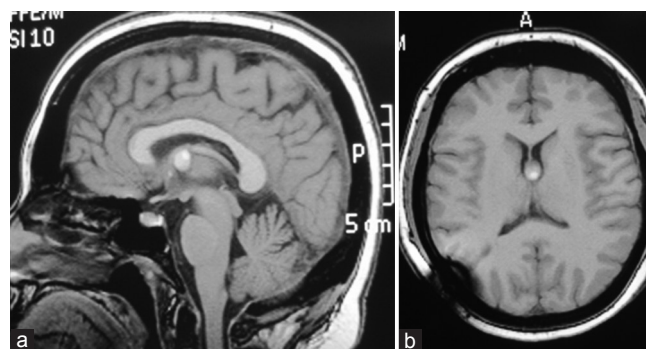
43 months Postoperative and Postradiosurgical Gammaknife treatment MRI views (a) Sagittal T1 weighted cerebral MRI showing that the third ventricular colloid cyst has remained essentially the same with complete resolution of the hydrocephalus. Corpus callosum with normal thickness. (b) Axial T1 views of the same patient
